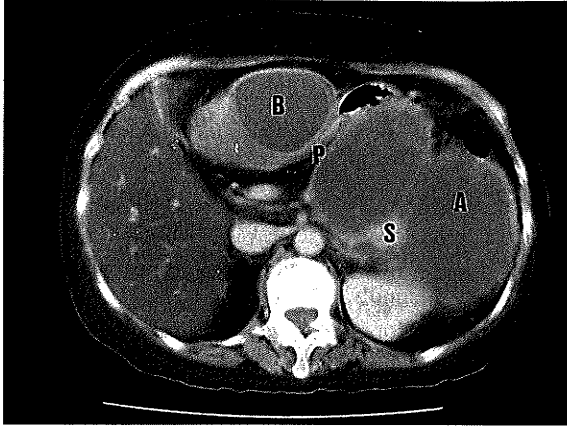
Enhanced CT of the upper abdomen (10 mm caudal to Fig. 2). A large hypodense lesion (A), measuring 10x15 cm is visible in the left subphrenic space encasing the splenic vein (S) and indented the posterior wall of the stomach (P), while a smaller lesion (B) measuring 9x4 cm is evident in the epigastrium region.
